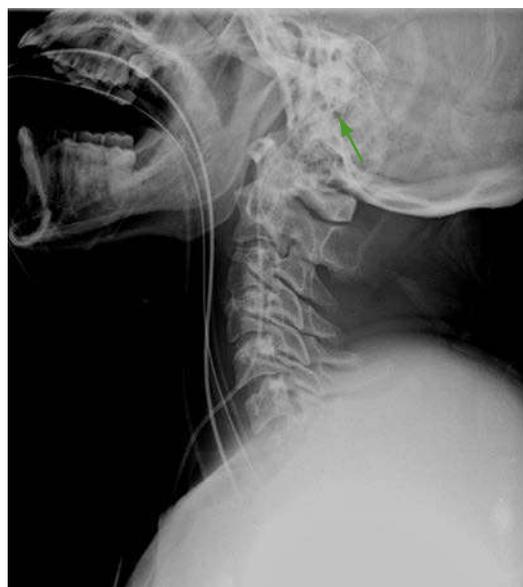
Lateral cervical spine radiograph showing appropriate positioning of the jugular venous oximetry catheter above the lower border of the C1 vertebra (the arrow tip is actually within the jugular foramen).
